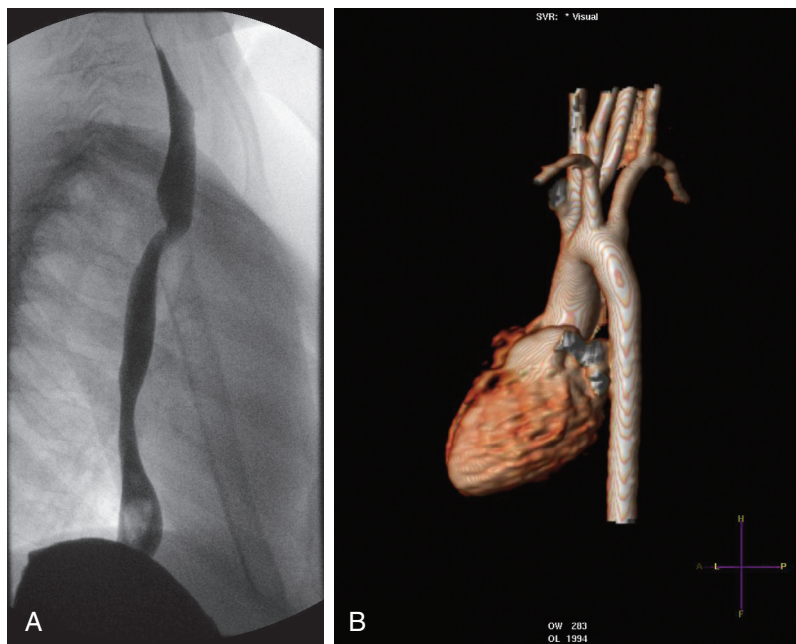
■ A, Esophagogram showing posterior indentation of the esophagus secondary to vascular compression. B, Three-dimensional magnetic resonance imaging reconstruction revealing an aberrant right subclavian artery in the same patient.
